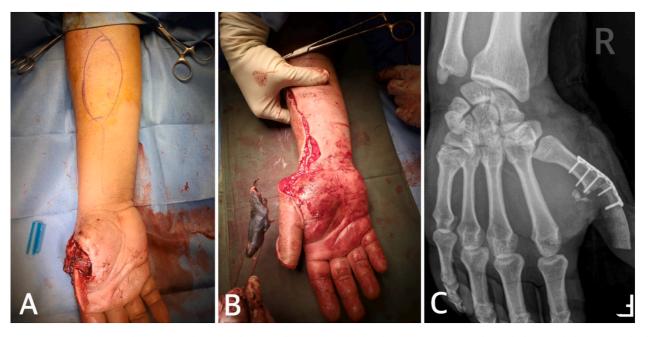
Intraoperative (A) Iliac crest bone graft with (B) radial forearm flaps on the right thumb. Postoperative (C) radiograph show good alignment of the thumb.
